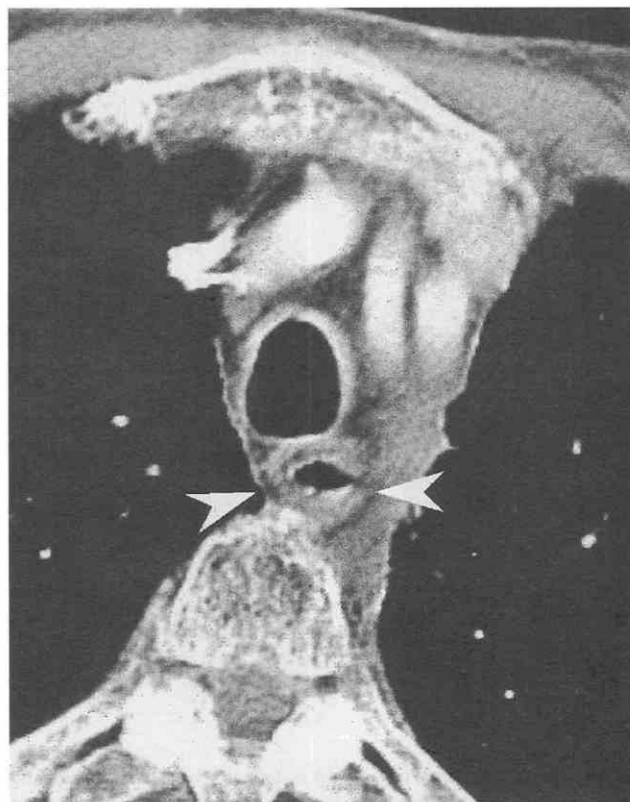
Esophagitis. CT scan shows circumferential esophageal wall thickening with the "target sign" (arrowheads). The esophageal fat is preserved in esophagitis, which is a point of differentiation from esophageal carcinoma.
